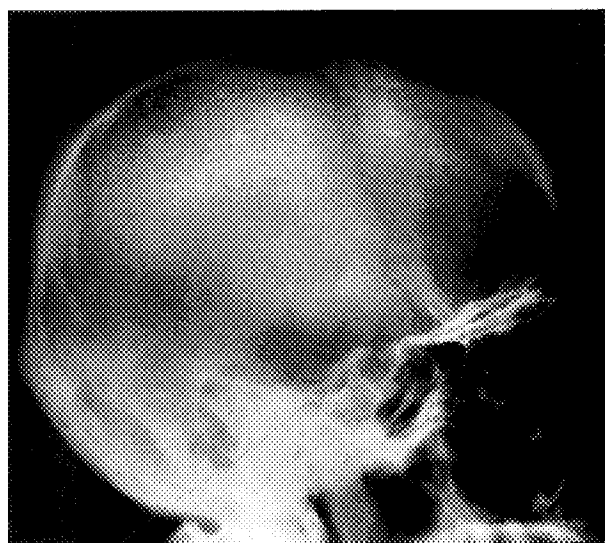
Lateral radiograph of skull showing normal sella turcica but thickening of the calvarium.
